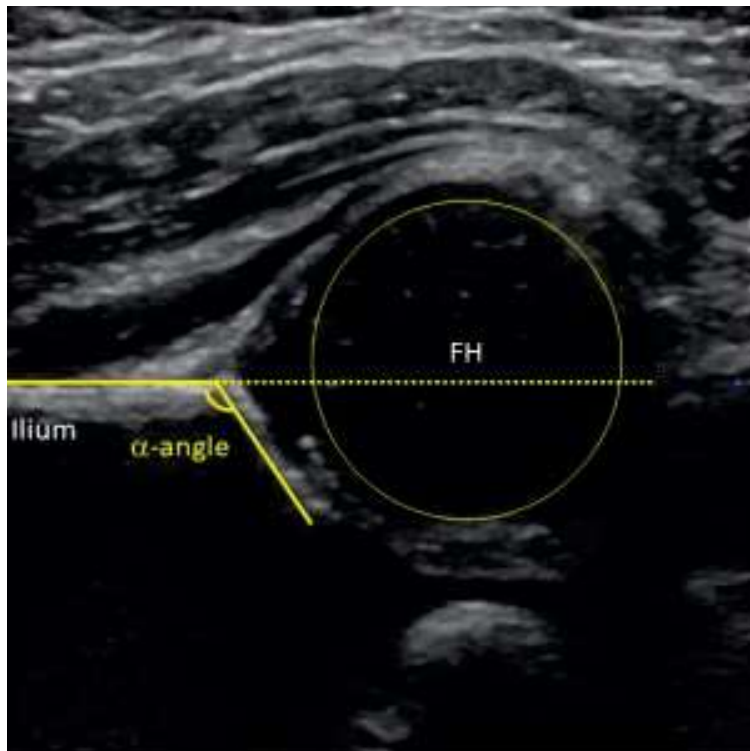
Ultrasound image demonstrating a normally developing hip. Note that the femoral head is bisected by a line drawn from the ilium (dotted line).
